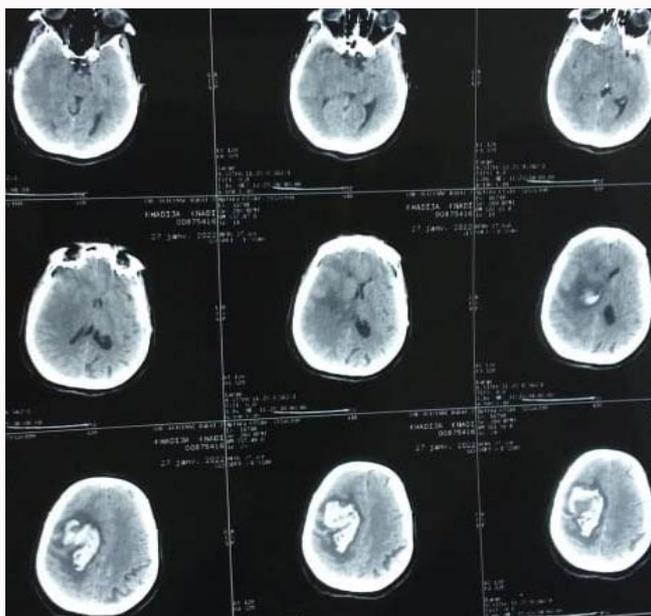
Cerebral CT scan. Axial section, parenchymal window, non-injected; showing a spontaneously hyperdense left frontal lesion associated with perilesional edema making a mass effect on the midline.
